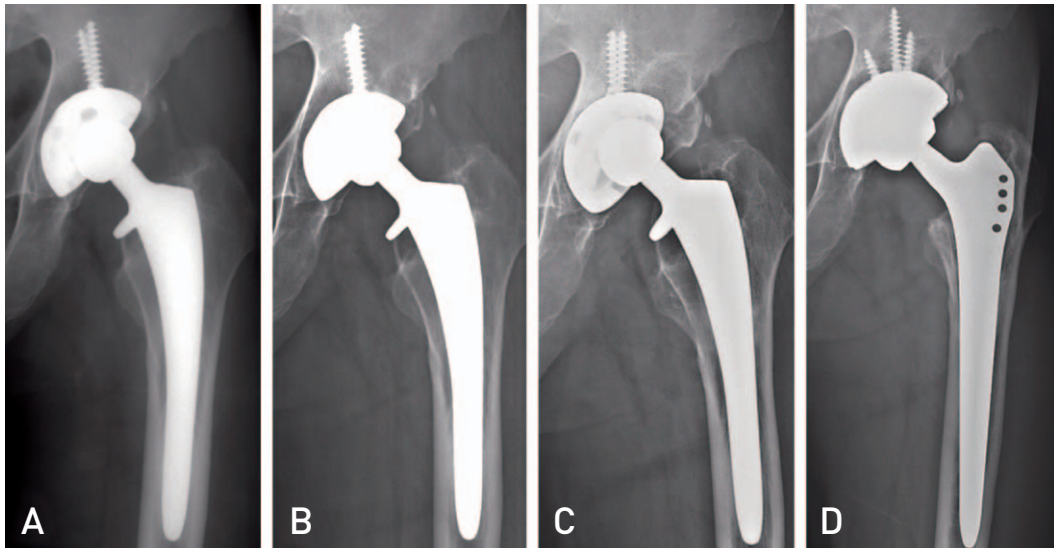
(A) Radiograph of a 51 year old patient at 10 years of follow-up. (B) A focal acetabular osteolysis was seen in zone 1 at 13 years of follow-up. (C) Progression of the osteolysis and cup migration were seen at 19 years of follow-up. (D) Revision total hip arthroplasty was performed.
